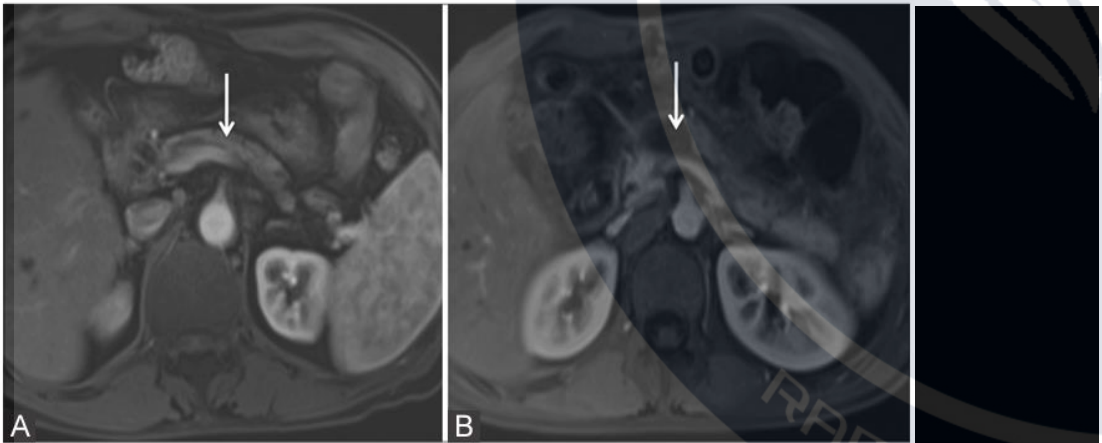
(A and B): MRI findings in chronic pancreatitis: Axial T1-weighted contrast enhanced MRI (A) shows reduced T1-weighted signal of the pancreas (arrow). Axial T1-weighted contrast enhanced MRI in another patient (B) shows mild reduction in bulk with a cystic lesion in neck of pancreas (arrow)
